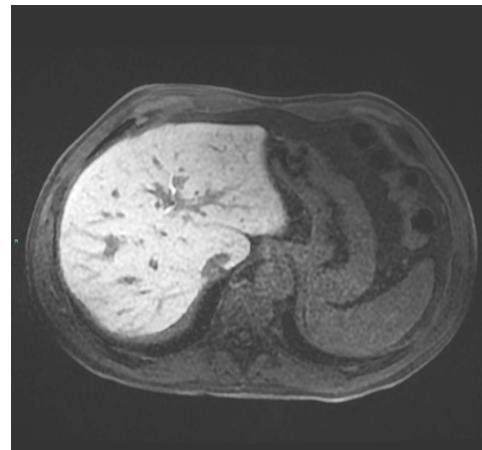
April 2024 MRI hepatobiliary phase image with hepato-specific agent showing complete response on liver parenchyma.
